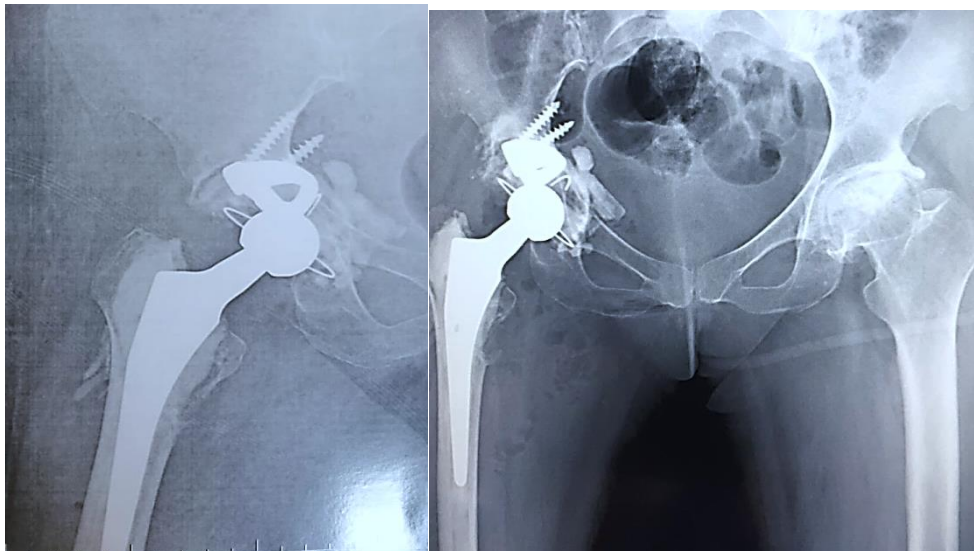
follow up x-ray after 3 months
